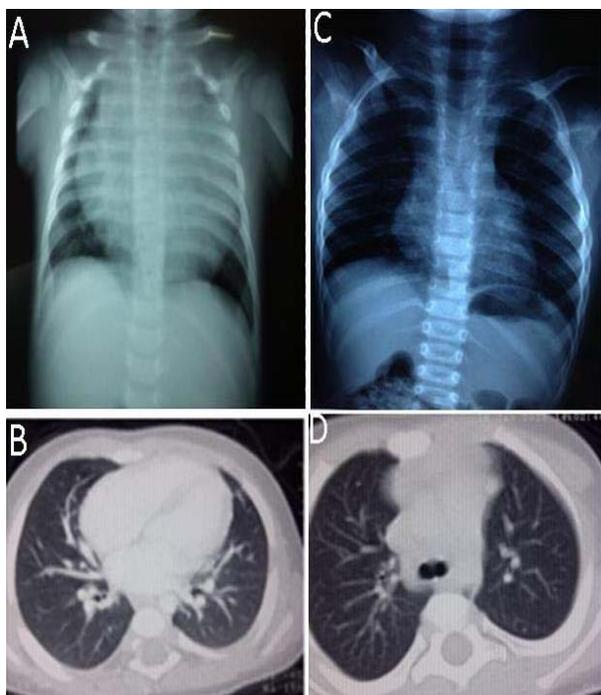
Chest X-ray and CT thorax showing large mediastinal mass pre-chemotherapy (A, B) and good response post-chemotherapy (C, D).
